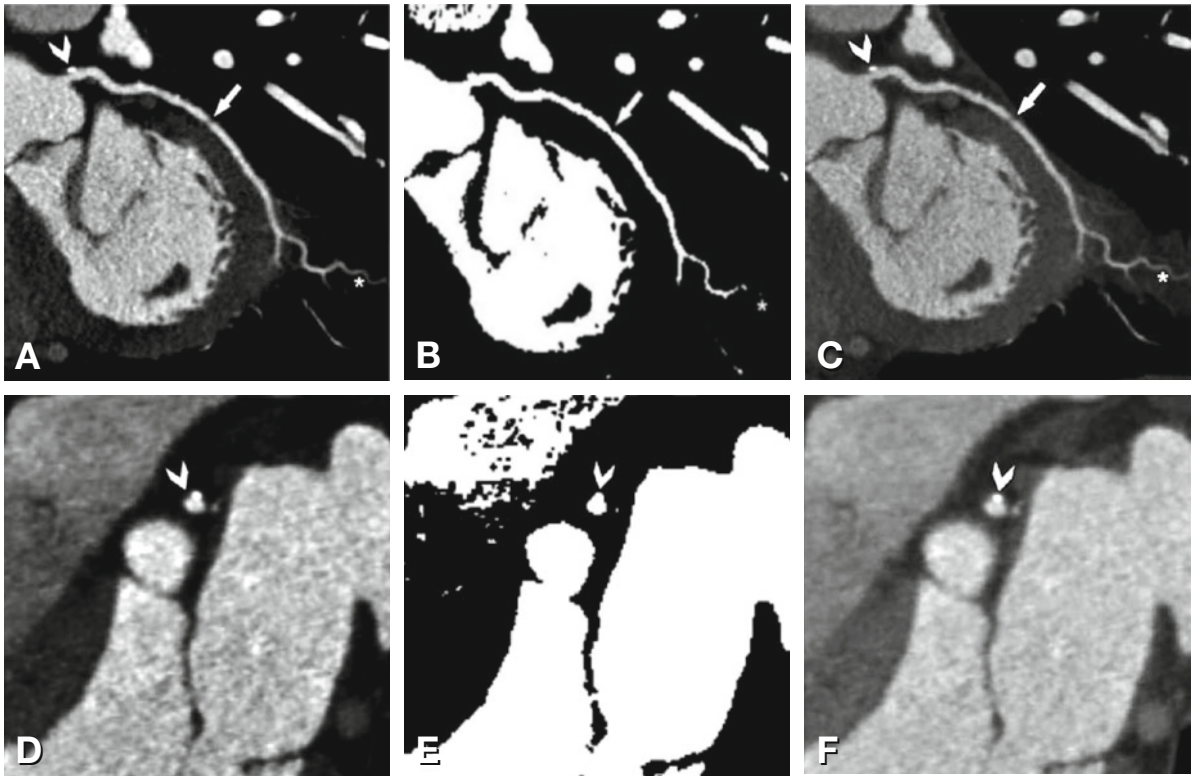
Specific window-level settings may be used for different coronary artery plaques. The *upper row* presents curved multiplanar reformations along the left circumflex coronary artery, and the *lower row* presents cross-sections orthogonal to the left main coronary artery (as indicated by the direction of the *arrowhead* in Panel A). Noncalcified coronary plaques and outer vessel boundaries are best visualized using a window representing 155% of the mean density within the coronary lumen and a level representing 65% of the mean density within the lumen as described by Leber et al. (Chap. 14). (Panels A and D; this is very commonly equal to 600–700/250–300 HU settings). The noncalcified plaque in the left main coronary artery is nicely seen on the cross-section in Panel D (*arrowhead*), and distal vessel segments are depicted on the curved multiplanar reformation using these settings (*asterisk* in Panel A). Optimal measurement of the coronary lumen, however, is obtained by keeping the level constant at 65% of the mean lumen density while reducing the window width to 1 (Panels B and E). Using these settings yields the most accurate measurement of the diameter stenosis in comparison to intravascular ultrasound (in this case 55% diameter reduction) as shown by Leber et al. The drawbacks of these settings include the fact that distal vessel segments are not seen as well (*asterisk* in Panel B), and calcified plaques are no longer discernible from the lumen (*arrowhead* in Panel E). Using more bone-window-like settings (e.g., 1,300/300 HU here), as shown in the last column, reduces the artifacts caused by calcifications and results in less overestimation of calcified coronary plaques than when standard settings are used (*arrowhead* in Panels C and F)
